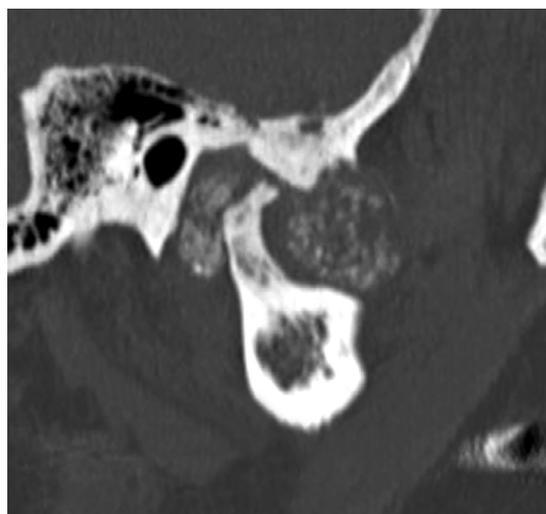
Sagittal reformat of noncontrast-enhanced CT shows flocculent whorl-like calcifications anterior and posterior to the condyle in the soft tissues surrounding the joint. The condyle is anteriorly displaced by the posterior mass and resorbed posteriorly by this same mass. The eminence is resorbed by the anterior mass. (Courtesy, R. Wiggins).
